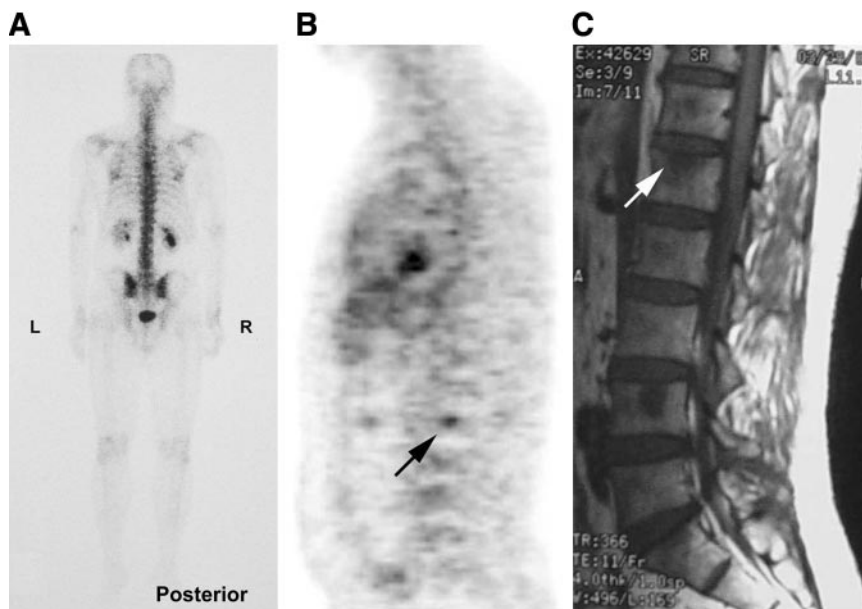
^{18}F -FDG PET and MRI scans of 42-y-old male NPC patient (undifferentiated cell type) with initial clinical stage of T1 N3b M0. Result of whole-body bone scan was negative (A). Unexpected L1-2 spine metastatic lesion was found on whole-body ^{18}F -FDG PET scan (B, arrow) and later confirmed by MRI (C, arrow).
